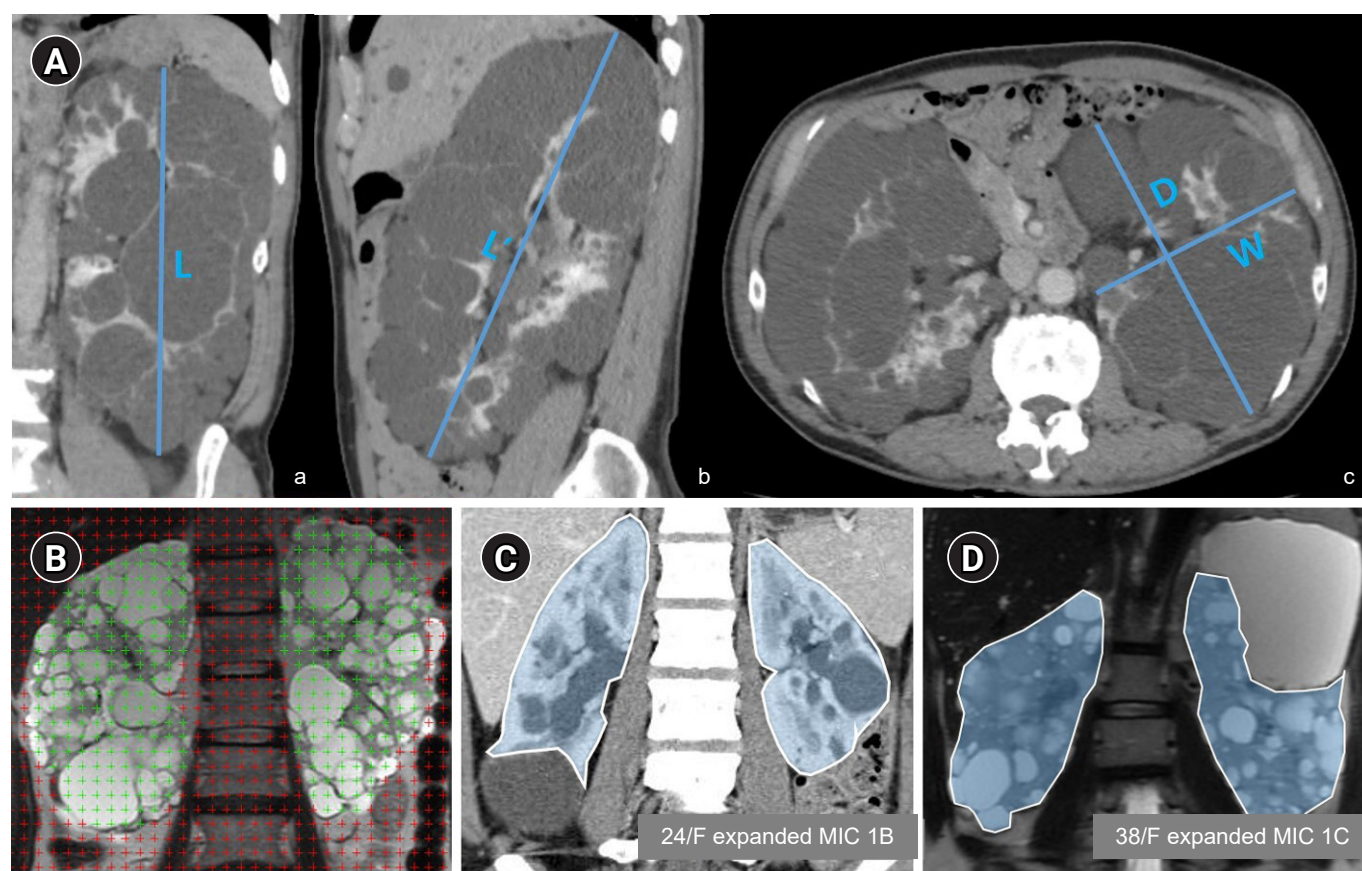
Manual techniques available for estimating TKV in patients with ADPKD. (A) Ellipsoid formula applied to a coronal slice (a) and a sagittal slice (b); measurements of longitudinal length ($L+L'/2$), maximum width (W), and maximal depth (D) are used to calculate renal volume in the typical ADPKD calculator web-based application provided by the Mayo Polycystic Kidney Disease Center. (B) Stereology applied to a coronal slice using MRI; grid points covering both kidneys are defined. (C) Planimetry method is applied to a coronal slice on a contrast-enhanced CT image; all slices are manually traced with kidney. Coronal CT image from an expanded MIC 1B patient: a 24-year-old woman with *PKD1* gene mutation whose baseline TKV decreased from 594 mL (MIC 1C) to 389 mL (MIC 1B) after the exclusion of exophytic cysts. (D) Coronal MRI from an expanded MIC 1C patient: a 38-year-old woman with *PKD1* gene mutation whose baseline TKV decreased from 1,236 mL (MIC 1D) to 940 mL (MIC 1C) after the exclusion of exophytic cysts. TKV, total kidney volume; ADPKD, autosomal dominant polycystic kidney disease; MRI, magnetic resonance imaging; CT, computed tomography; MIC, Mayo imaging classification.
